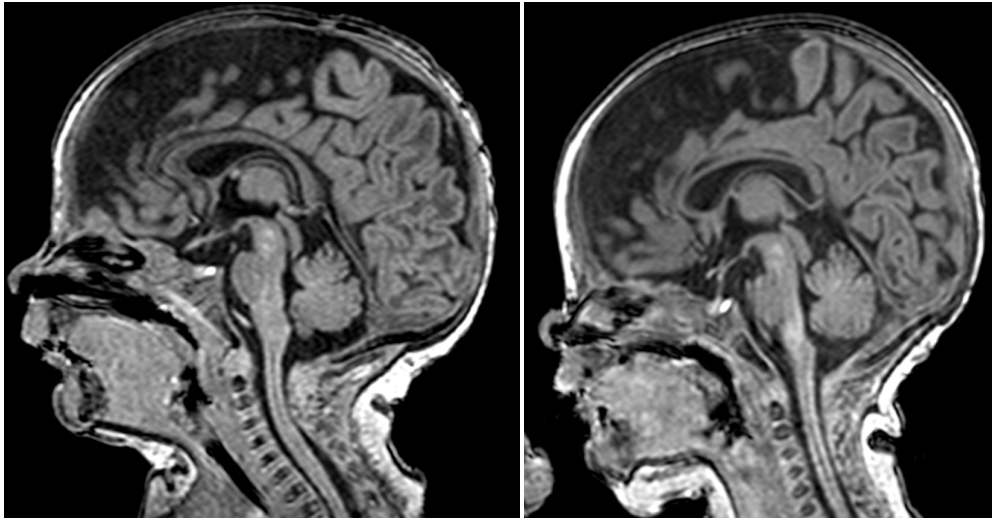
T1 weighted midline sagittal MR image showing normal sized CC and b. small sized CC
